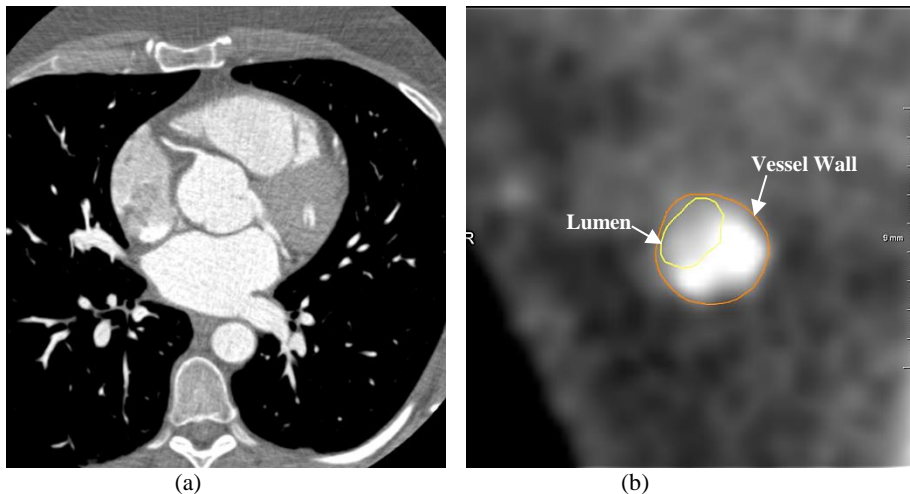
The coronary CTA image. (a) a slice of a coronary CTA image; (b) a close-up image of the coronary artery on 2D axial view with lumen and vessel wall contour highlighted.
